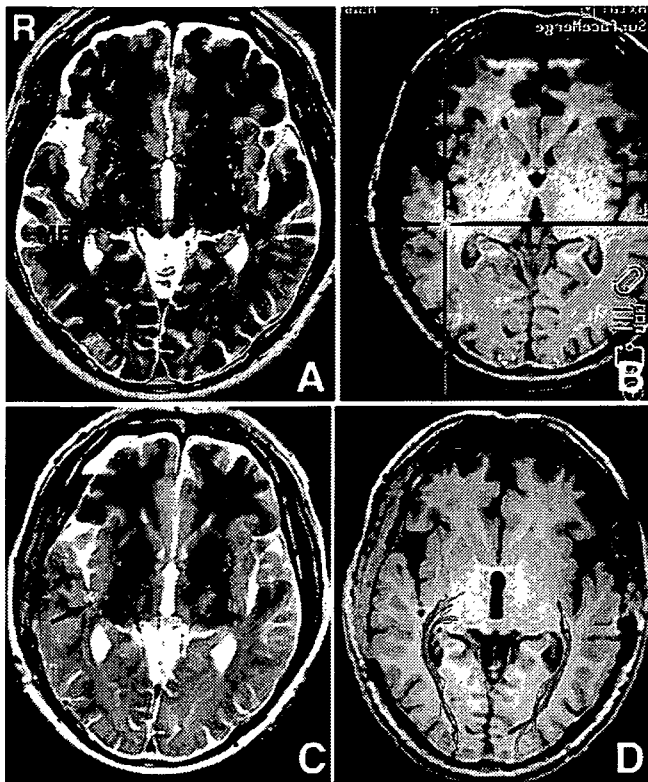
A: Preoperative T₂-weighted magnetic resonance (MR) image showing the microbleed in the right temporal operculum (MB1) located near the right optic radiation. B: MB1 was resected under monitoring of the optic radiation using a MR tractography-guided navigation system (blue bundles indicating optic radiation). C: Postoperative T₂-weighted MR image at 1 month after surgery showing removal of MB1 (arrow). D: MR tractography image at 3 months after surgery demonstrating preservation of the right optic radiation.
